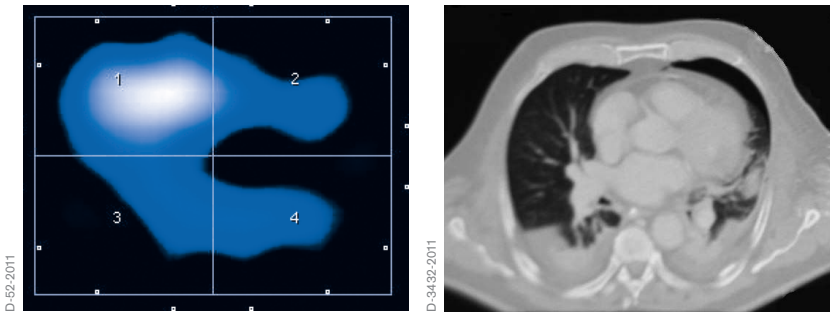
Tidal image and corresponding CT image of a patient with a pneumothorax in the left lung
